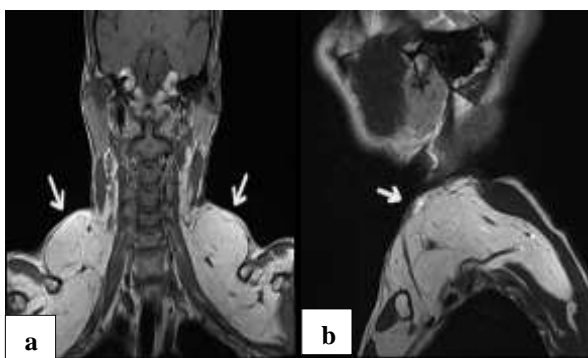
(a and b): MRI of the neck and thorax.
